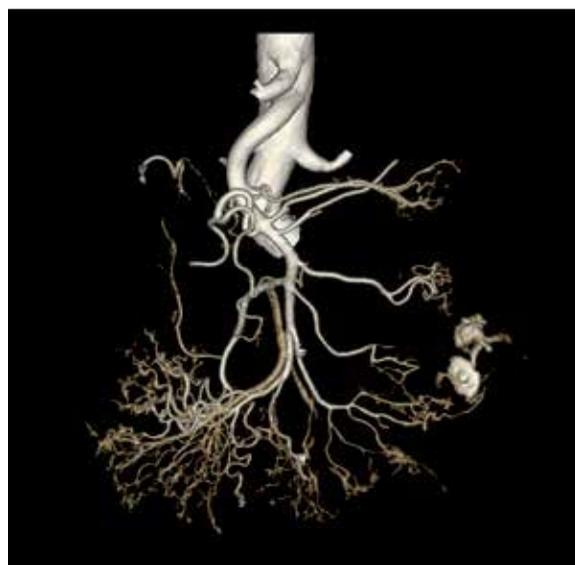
Volume rendering (VR) reconstruction of angio-CT scan clearly demonstrating contrast extravasation.
